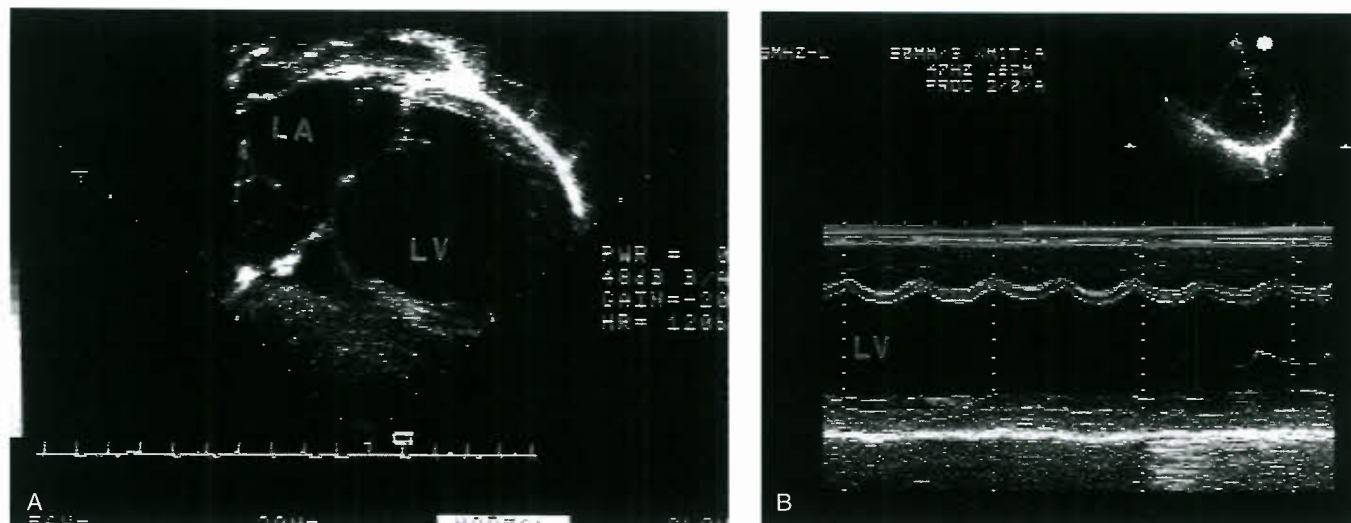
A: Two-dimensional echocardiographic findings of a patient with dilated cardiomyopathy. Note the severely dilated left atrium and ventricle. B: M-mode findings of another child with congestive cardiomyopathy. Note the large chamber dimensions and the depressed systolic wall motion. LA, left atrium; LV, left ventricle.
